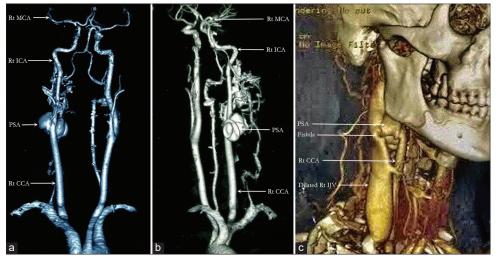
Pre-operative computed tomography angoigraphy showing pesudo aneurysm at the bifurcation of right CCA.
